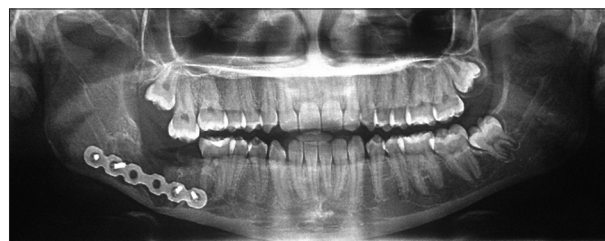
Final panoramic radiography
